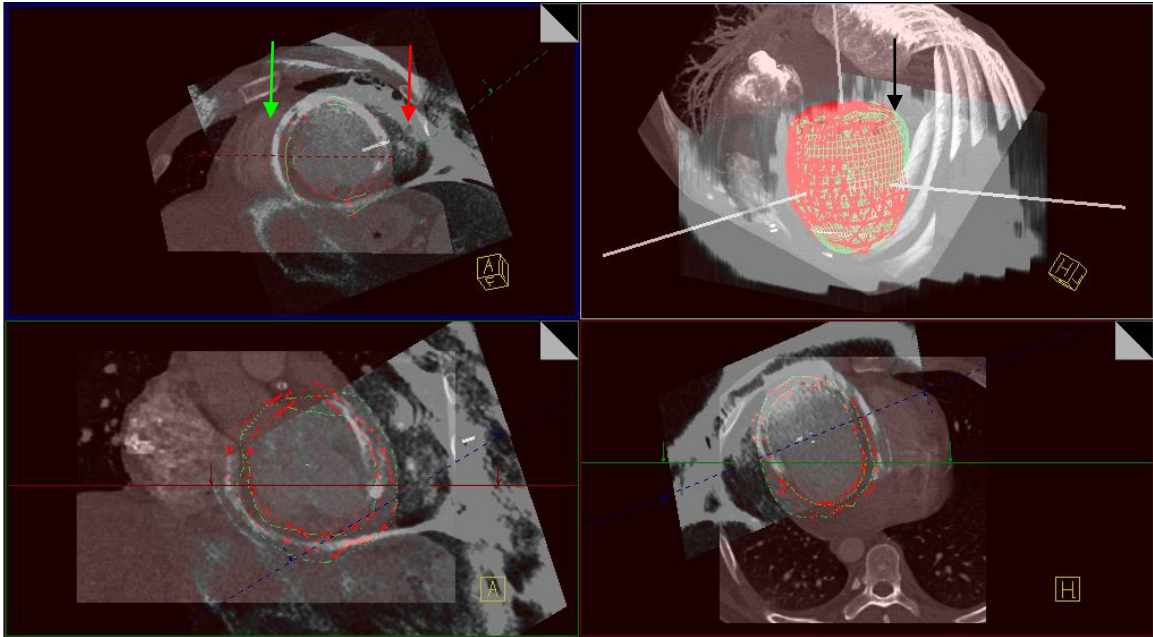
Result of registration initialization using principal components for Patient 1. The black arrow seen in the rendered volume view indicates the location of misalignment of LV surface points from DEMR and CTA. The top left view shows the difference in orientation noticeable with the orientation of the RV in DEMR (red arrow) and CTA (green arrow).
